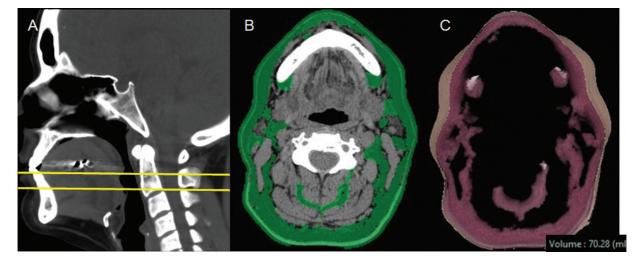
Cervical fat volume quantified by CT. (A) Sagittal reconstruction showing the region of interest between lowest tip of the soft palate and the highest portion of the epiglottis. (B) Segmentation carried out with semiautomatic analysis of the Hounsfield units. (C) Fat tissue extracted for 3D image reconstruction and fat volume measurement.
